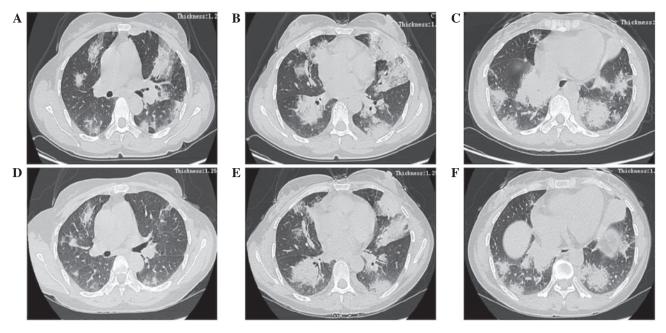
CT scans performed at initial presentation and 6 months post-steroid treatment. Initial CT scans showing (A) multifocal nodules with poorly-defined margins and ground-glass changes in the upper and middle lobes and (B) diffuse areas of patchy or airspace consolidation distributed along the bronchovascular bundle or pleura in both middle and lower lobes. (C) Initial CT scans of the middle and lower lobes showing multiple peripheral lung nodules and consolidation distributed along the pleura prior to steroid treatment. Chest CT scans performed after 6 months of steroid treatment showing that (D) small areas of ground-glass change were partially absorbed, and (E) the patchy consolidation was not alleviated following treatment. (F) No changes in the peripheral lung nodules and consolidation were observed subsequent to steroid treatment CT, computed tomography.
